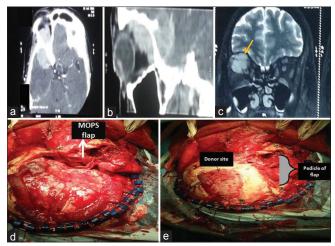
(a and b) Preoperative computerized tomography films showing the medial sphenoid wing meningioma destroying anterior skull base and orbital roof. (c) Preoperative coronal magnetic resonance imaging picture showing the orbital part of meningioma (orange arrow shows meningioma). (d) Intraoperative picture after Frontoorbito zygomatic craniotomy. (e) Bone flap replaced showing donor area. Moulded osteomyofascial pedicled split craniotomy flap is fashioned and seated to cover anterior cranial fossa defect. The flap is highlighted using grey bracket
